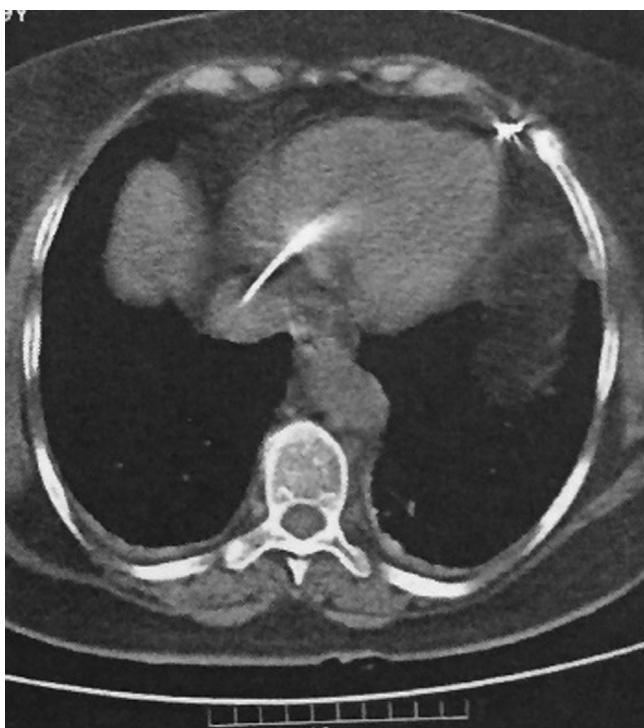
Chest computed tomography. Perforation of the right ventricular apex 2 months after pacemaker implantation.
